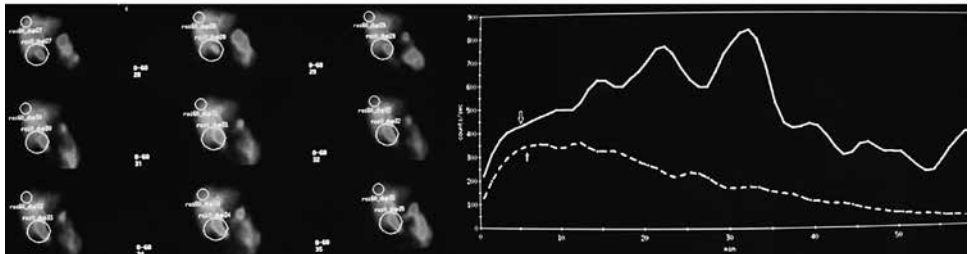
Representative scintigraphic images taken one month apart (Panel A and Panel B) following IV administration of 185 MBq ^{99m}Tc -BRIDA.
